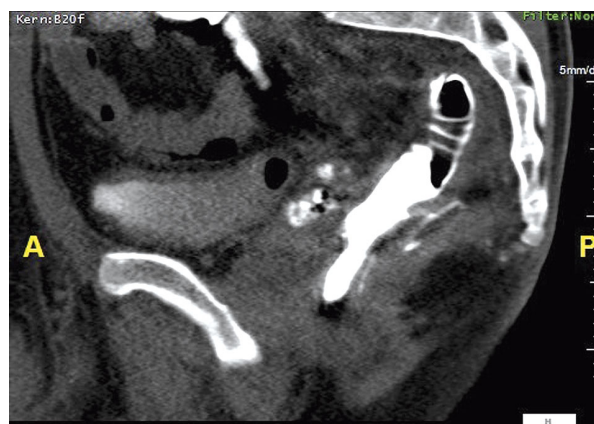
Computed tomography irrigoscopy. Presents a narrow stripe leading ventrally from the rectum with filling of both seminal vesicles
